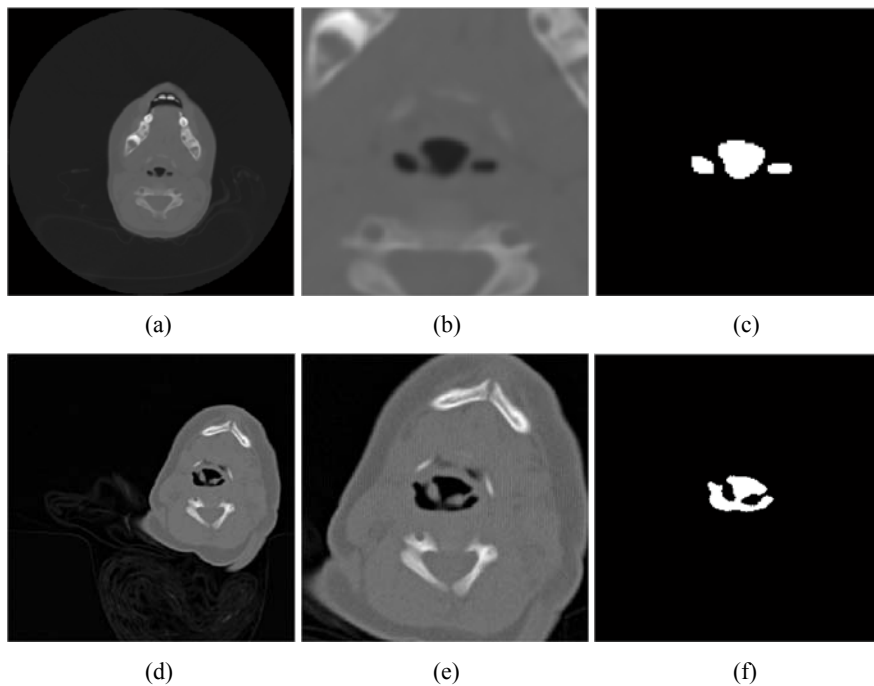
Outcome of region-growing segmentation performed on pathological datasets, (a,d) the original CT slice (b,e) detail of upper airways and (c,f) detail of the segmented upper airway ROI
